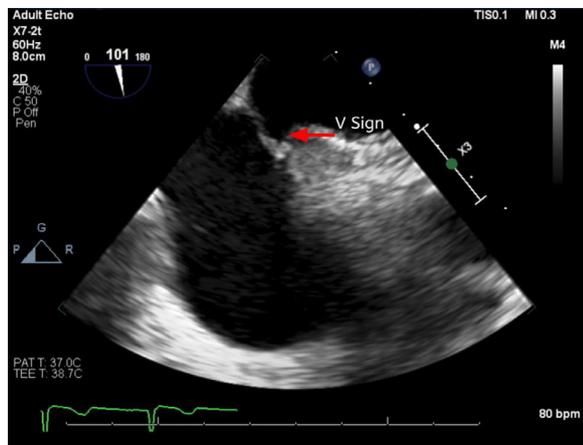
Transesophageal echocardiography demonstrating V-sign, a V-shaped indent on the septum primum, which reflects tension due to the NobleStitch KwiKnot.
